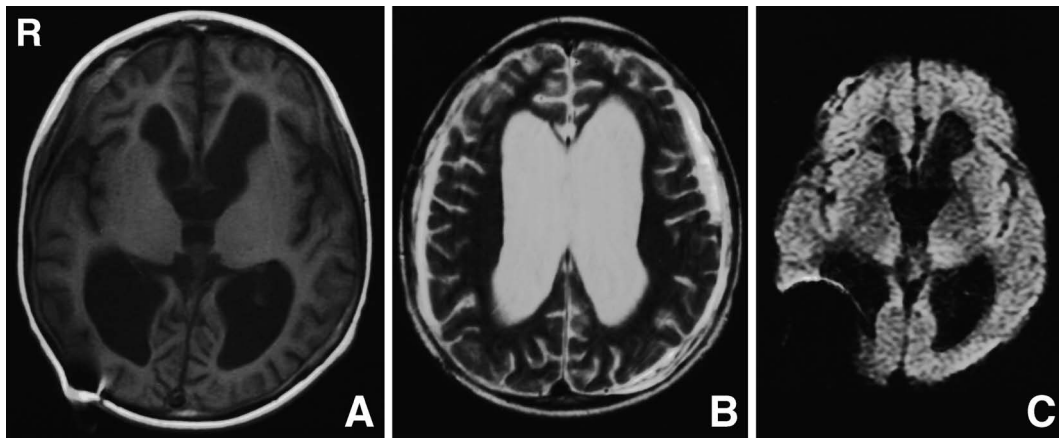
Axial T₁-weighted (A), T₂-weighted (B), and diffusion-weighted (C) magnetic resonance images obtained at follow-up examination 26 days after burrhole trephination for the left subdural hematoma demonstrating improved hydrocephalus and residual subdural hematoma.
